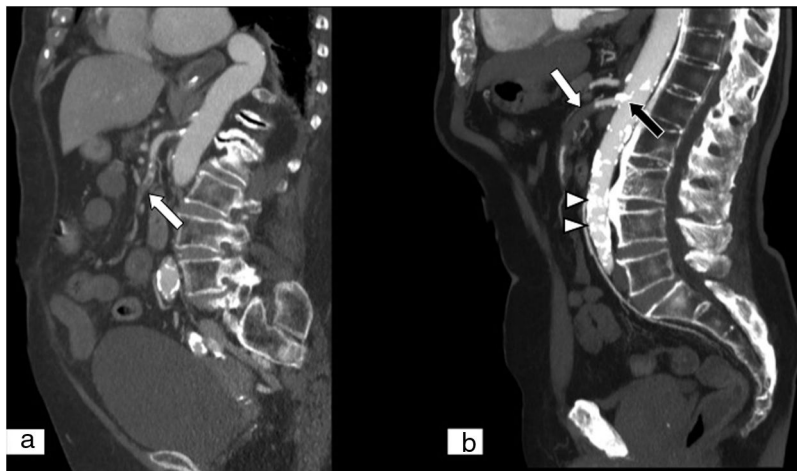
Mesenteric ischaemia of arterial origin. (A) Embolism of the superior mesenteric artery. Multiplanar reconstruction (MPR) on a sagittal plane in an abdominal and pelvic computed tomography (CT) scan with iodinated intravenous contrast in an arterial phase showing an embolus inside the superior mesenteric artery (white arrow), distal to the origin of the artery. (B) Thrombosis of the superior mesenteric artery. MPR on a sagittal plane in an abdominal and pelvic computed tomography (CT) scan with iodinated intravenous contrast in an arterial phase showing the presence of a thrombus in the main trunk of the superior mesenteric artery (white arrow) involving the first 2–3 cm from the origin of the artery. In addition, an atheromatous load greater than that seen in an embolic condition is visualised and striking calcifications due to atherosclerotic changes at the origins of the superior mesenteric artery (black arrow) and the abdominal aortic artery (white arrow tips) are observed.
